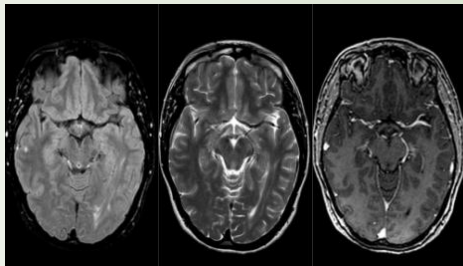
Brain MRI (FLAIR, T1, T2 with contrast enhancement) showing a left subcortical occipital lesion around the ipsilateral occipital horn, without mass effect and with absent contrast enhancement.
